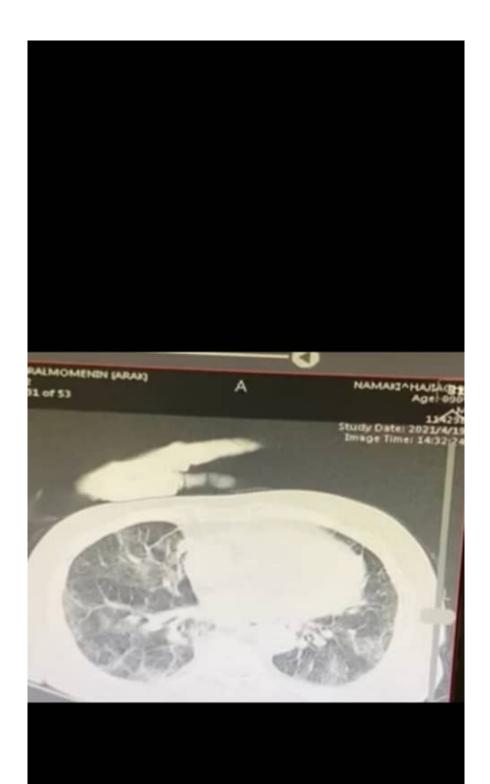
Chest CT scan revealed multiple vessel-related nodular opacities with grand glass halo with central and peripheral distribution, bilateral pleural effusion.
